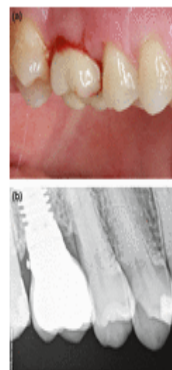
(a) Bleeding and swelling of peri-implant tissues around implant restoration; (b) Radiographic image of peri-mucositis. Crestal bone loss does not exceed acceptable norms.
